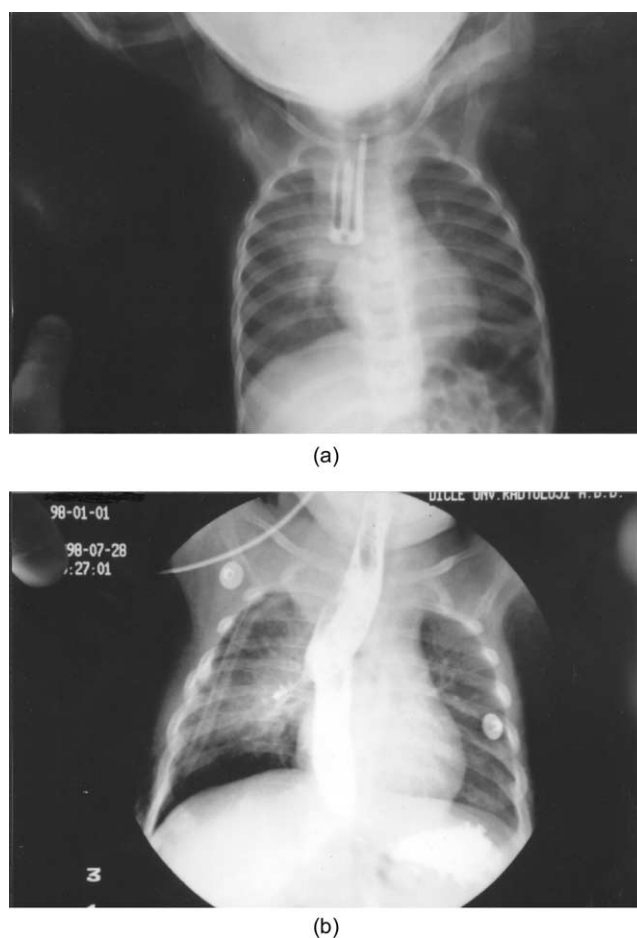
(a) A hairpin on plain film of 15-month-old child. (b) Postoperative esophagography with barium.
